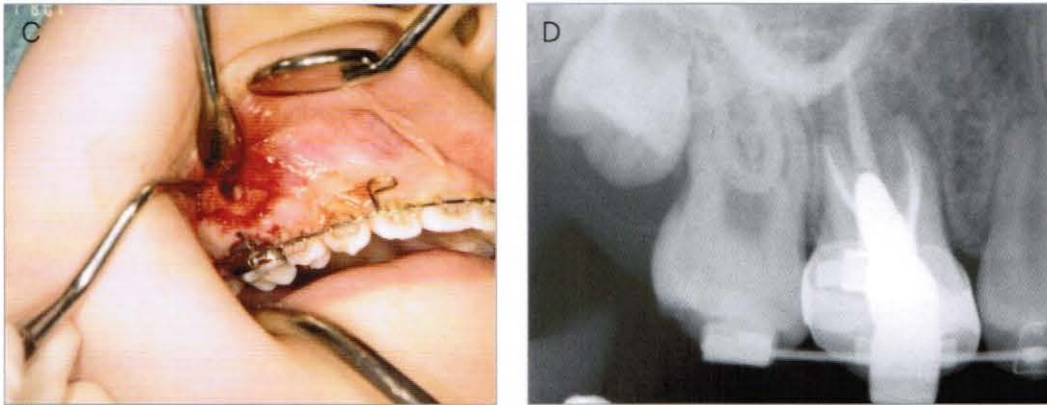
Pulpitis and periapical infection due to infection during mini-implant removal
